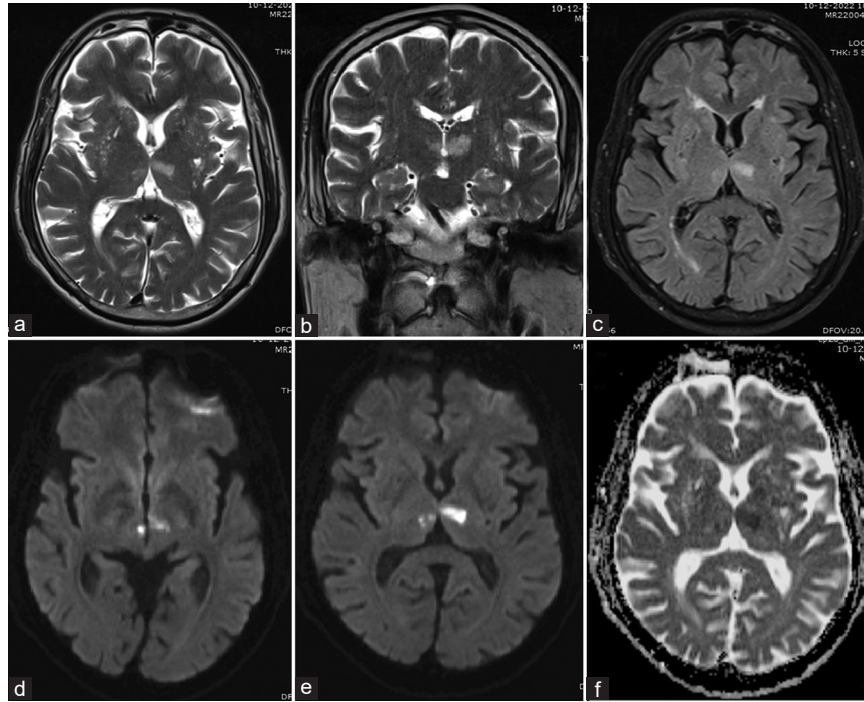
Magnetic resonance imaging showing bilateral paramedian thalamic hyperintensities in (a) T2 axial and (b) coronal (c) images as well as axial fluid-attenuated inversion recovery sequences. (d and e) The lesions show diffusion restriction on diffusion-weighted images sequences and (f) corresponding hypointensities on apparent diffusion coefficient sequences.
